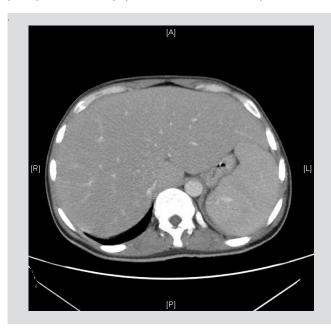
Abdominal computed tomography showing homogeneous hepatosplenomegaly (liver right lobe longitudinal diameter 20 cm; spleen cranial-caudal, antero-posterior and transverse diameters 17.6, 14 and 5 cm, respectively)
